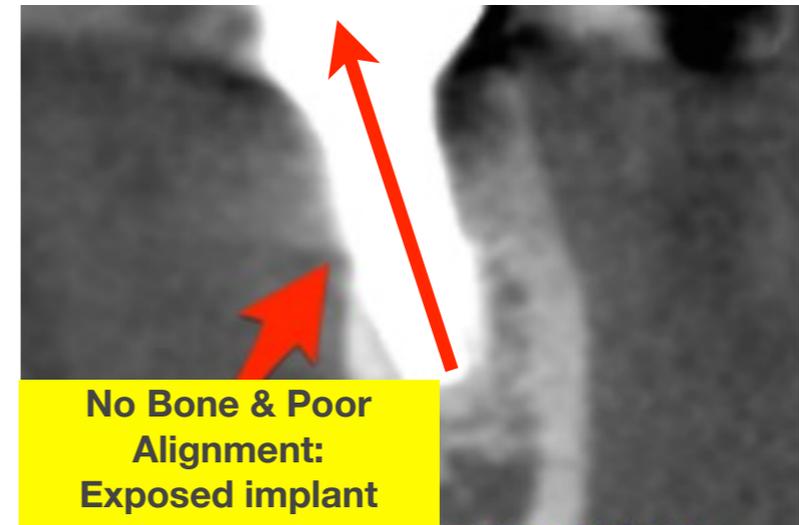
Shown in a cross section of a CT scan, this implant was placed off axis and misaligned with underlying bone which resulted in implant surface exposure and bone loss
